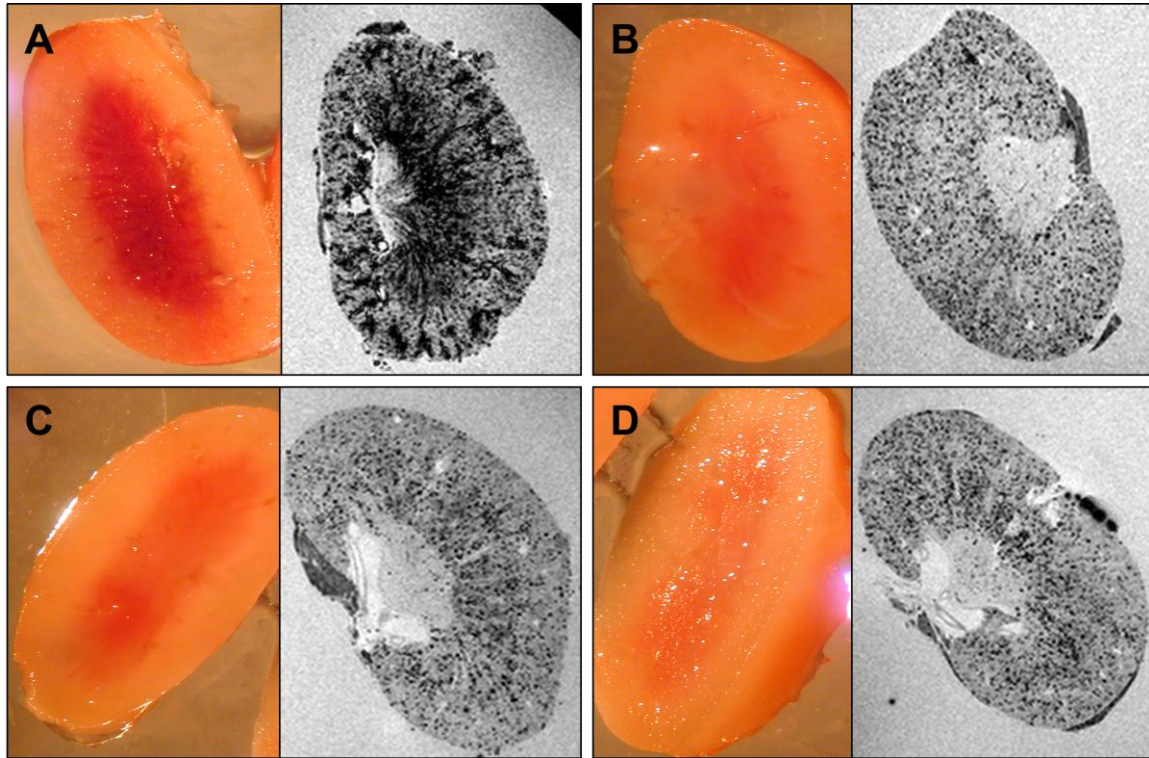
High-resolution *ex-vivo* MRI of PSEL-MPIO
